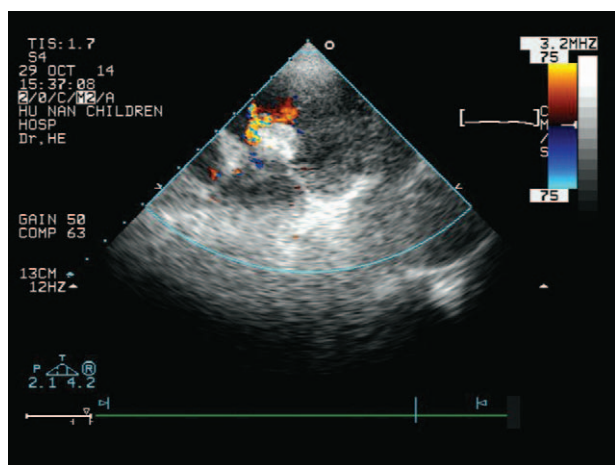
TTE after transcatheter pmVSD closure showing 1 mm residual shunt at the upper edge of occluder. pmVSD = perimembranous ventricular septal defect, TEE = transesophageal echocardiography.
